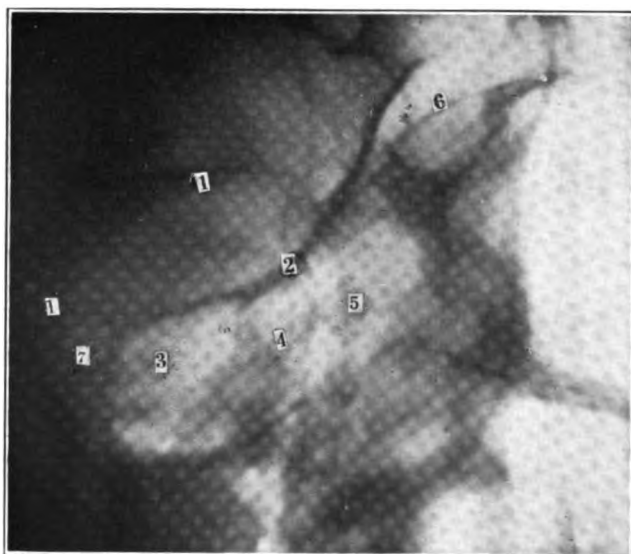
Roentgenogram of normal cavities in an adult (right side): 1, 1, orbital margin; 2, suture line; 3, sphenoid; 4, posterior ethmoids; 5, anterior ethmoids; 6, frontal sinus; 7, optic foramen.
